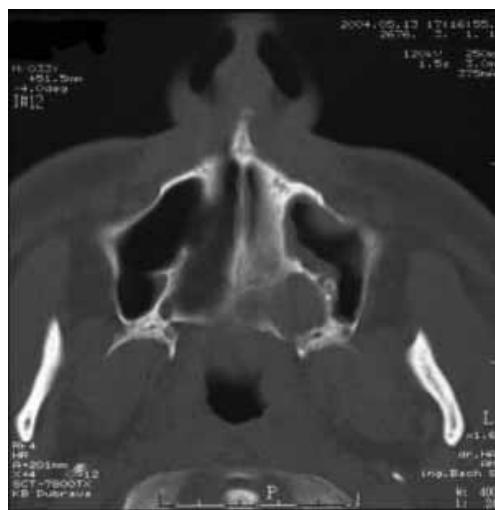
Axial CT scan shows the pathological process of a hard palate (25 mm in diameter) with a cystic bone transformation and a small bone infraction.
